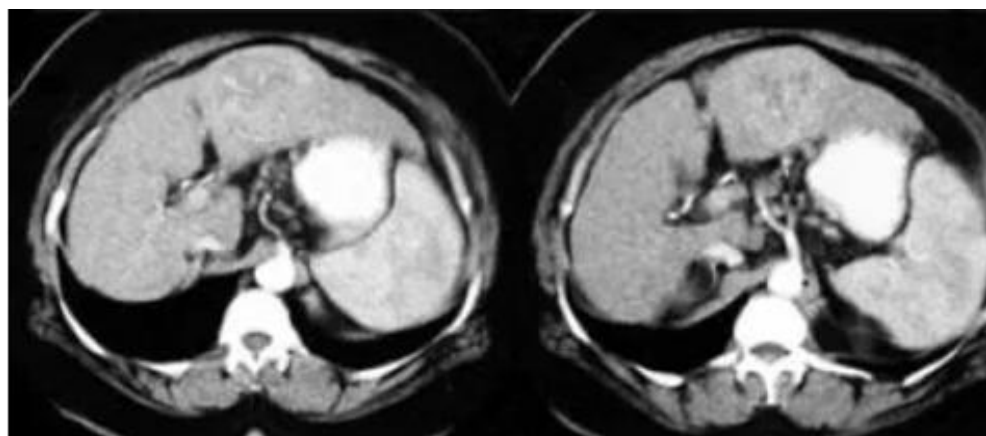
During the contrast enhancement hepatic arterial phase on CT scan, there is evidence of neovascularity in a low-density liver mass [12].
